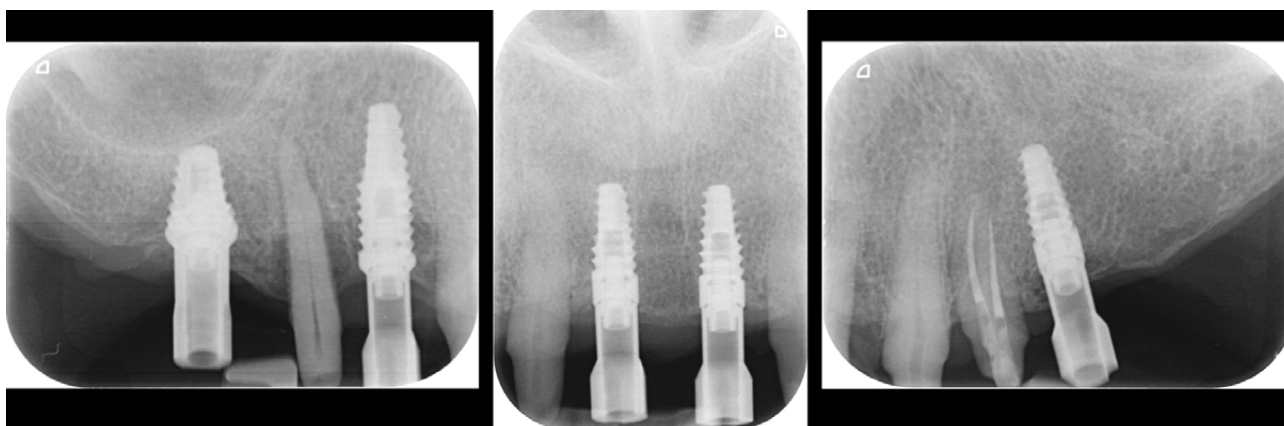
Periapical radiographs to verify the seat of the digital scan bodies.
